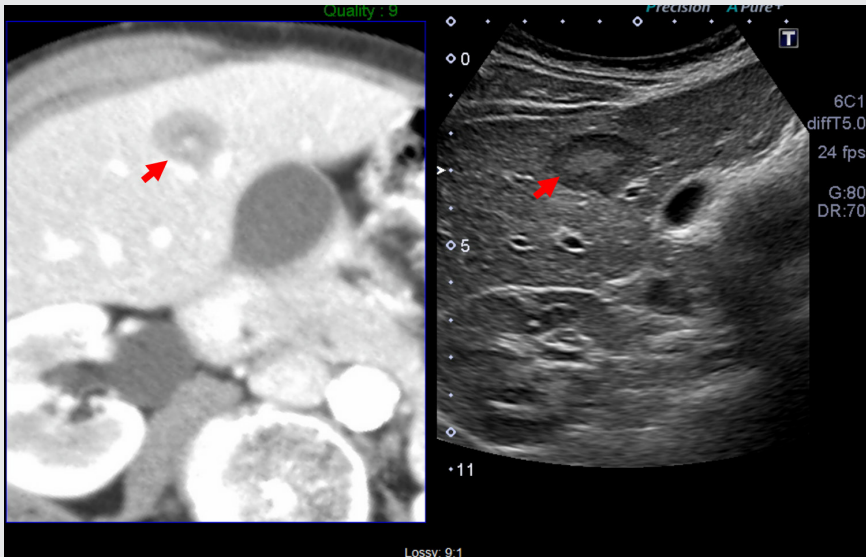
Synchronized CT image (left) and live ultrasound image (right) using Smart Fusion, demonstrating accurate co-localization of the liver mass.
